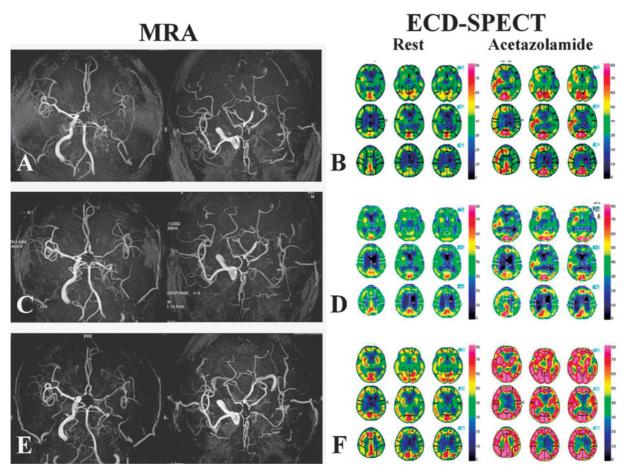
Follow-up MRA and SPECT
